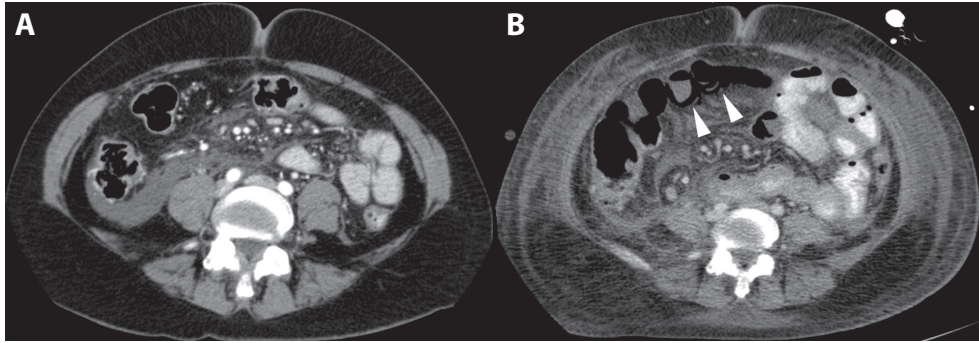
A 47-year-old woman with development of ACS occurring early in the course of acute necrotizing pancreatitis (same patient as Figure 6). (A) Contrast-enhanced CT (day 1) at the level of the umbilicus shows mesenteric and retroperitoneal inflammatory changes due to pancreatitis. Note, the normal configuration of the abdominal contour. (B) Repeat CT on day 4 shows a rounded appearance of the abdomen (round belly-sign). Also note, pneumatosis intestinalis and absent bowel wall enhancement of ileal loops (arrowheads), indicative for small bowel ischemia. Patient underwent emergency laparotomy.
